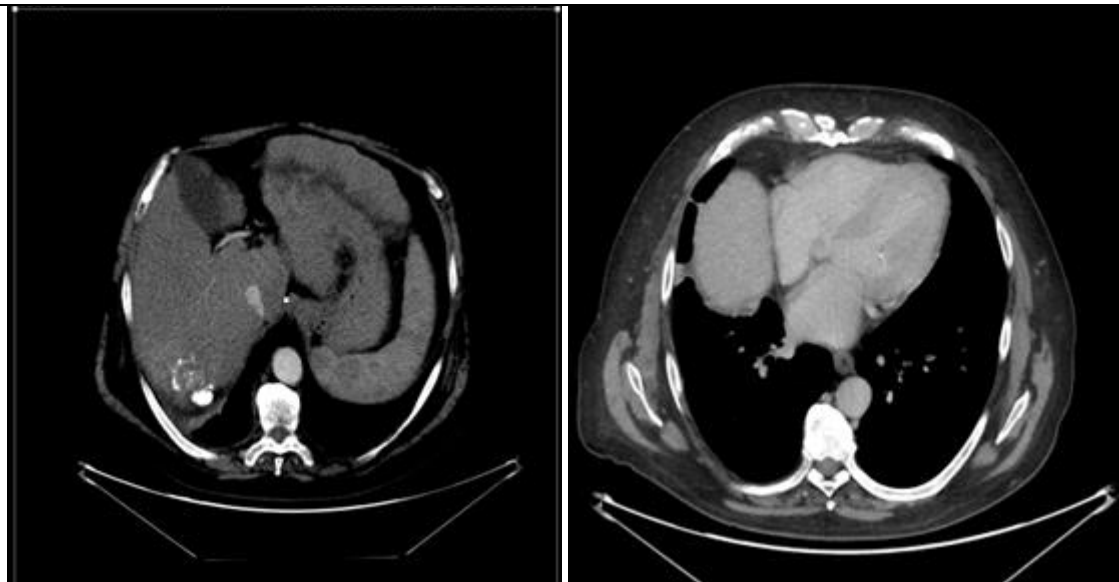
CT after 4 months from the treatment (TAELE + MWA) showed Lipiodol deposits at the level of target area, the absence of residues or new hepatic lesions and the resolution of pleural effusion with atelectasis of LID.
